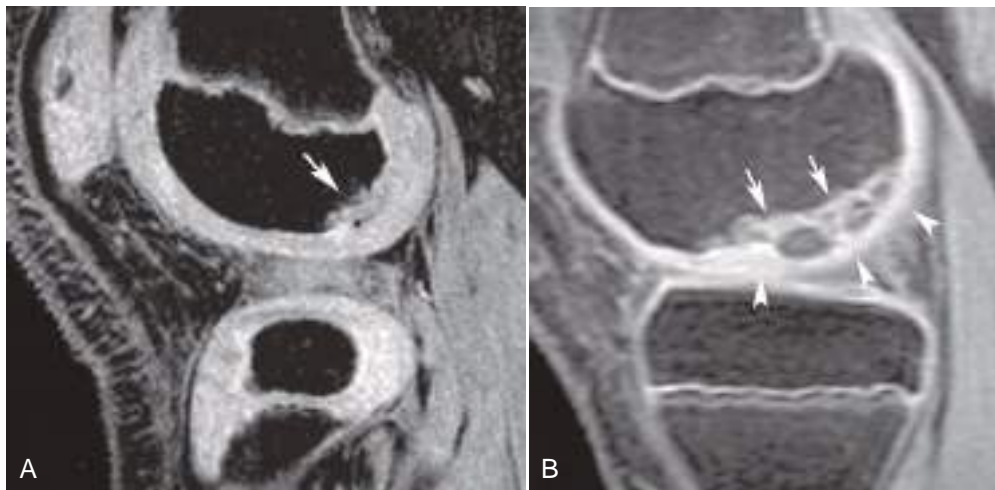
Disorders that mimic osteochondritis dissecans (OCD). Subchondral bone irregularity or fragmentation is a frequent finding in the posterior femoral condyles of children. (A) Sagittal fat-suppressed spoiled gradient-echo MR image shows corresponding finding of subchondral irregularity, with cartilage filling the defect. Note the normal contour of overlying articular cartilage. Also, fluid-sensitive sequences showed no marrow edema, which is another clue to a benign process. (B) More extensive fragmentation (*arrows*) in a different child, in this case with potential to progress to OCD. Note the intact overlying cartilage (*arrowheads*). Other sequences showed normal marrow signal, and the child had only minimal symptoms. These rather extreme findings resolved with restriction of the child's activities.
